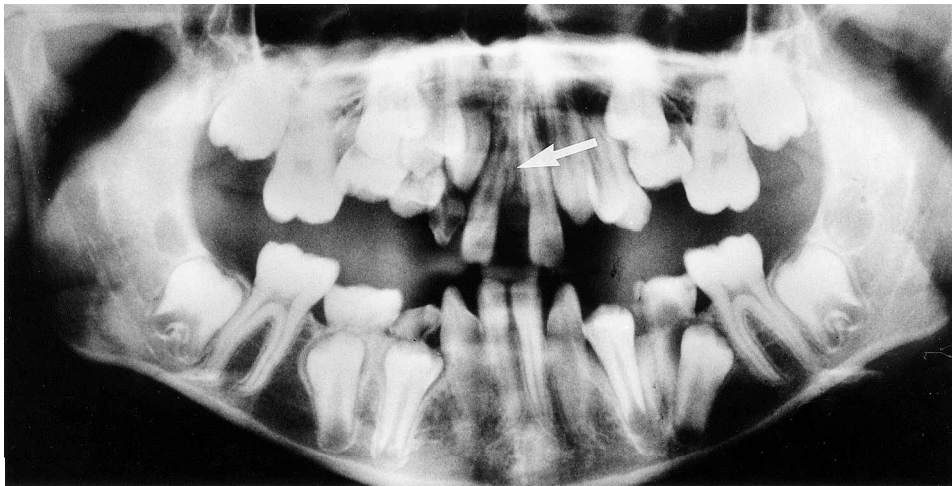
Orthopantomogram of two female subjects in whom the malformation in the area of the interincisal part of the intermaxillary suture can be observed. Absence of the sutures in the regions marked by arrows.
